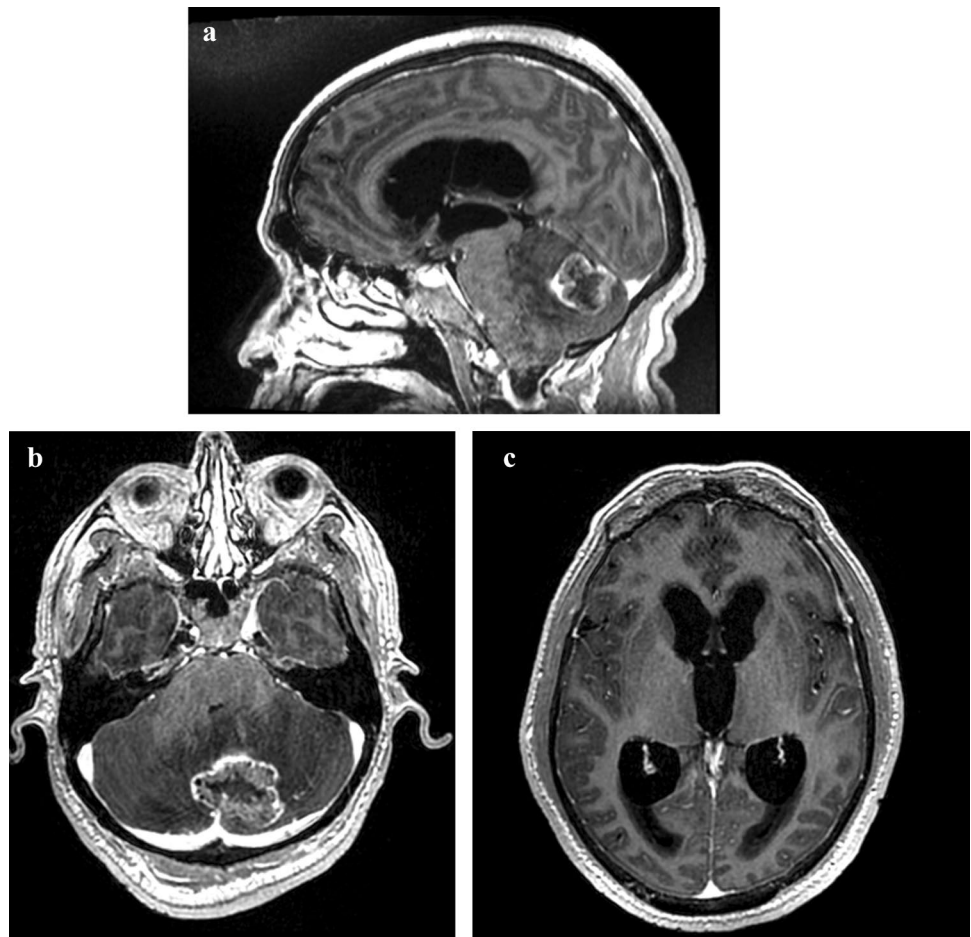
40-year-old female with a history of breast cancer. a T1-weighted gadolinium-enhanced magnetic resonance (MR) images in the axial plane show a heterogeneously enhancing lesion in the left
